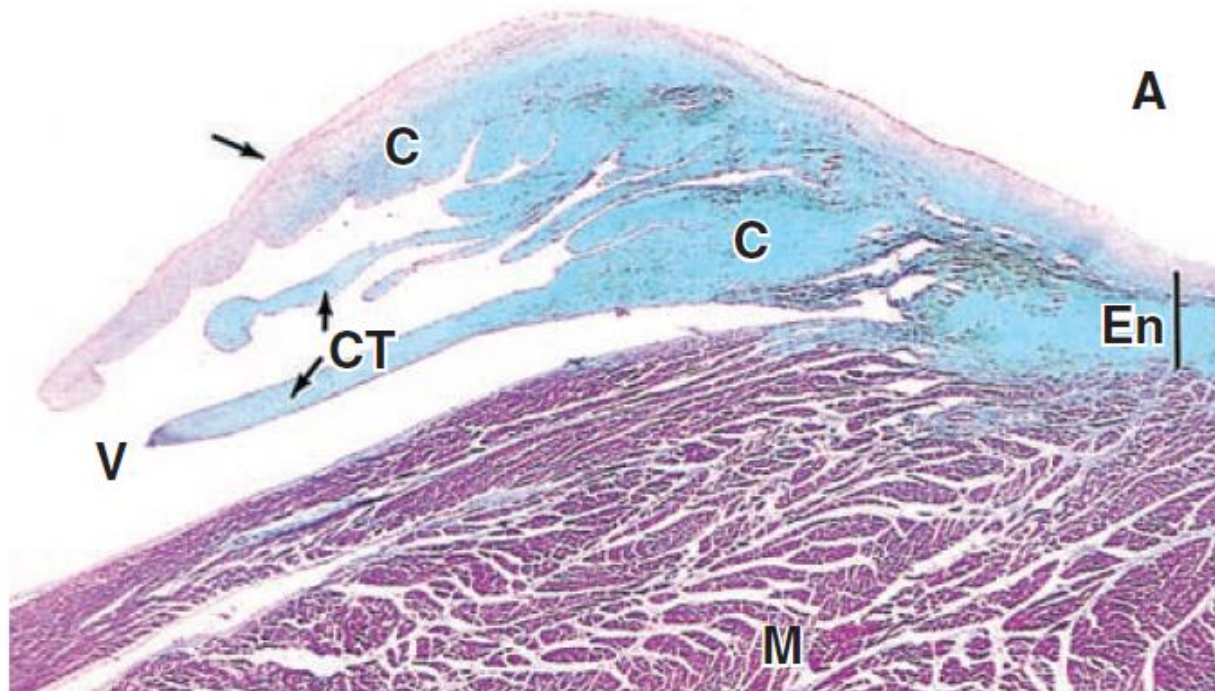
Atrioventricular valve (arrow) between atria (A) and ventricle (V). Note the core of fibrous connective tissue (C) which extends into the chordae tendinea (CT). En, endocardium; M, myocardium.
